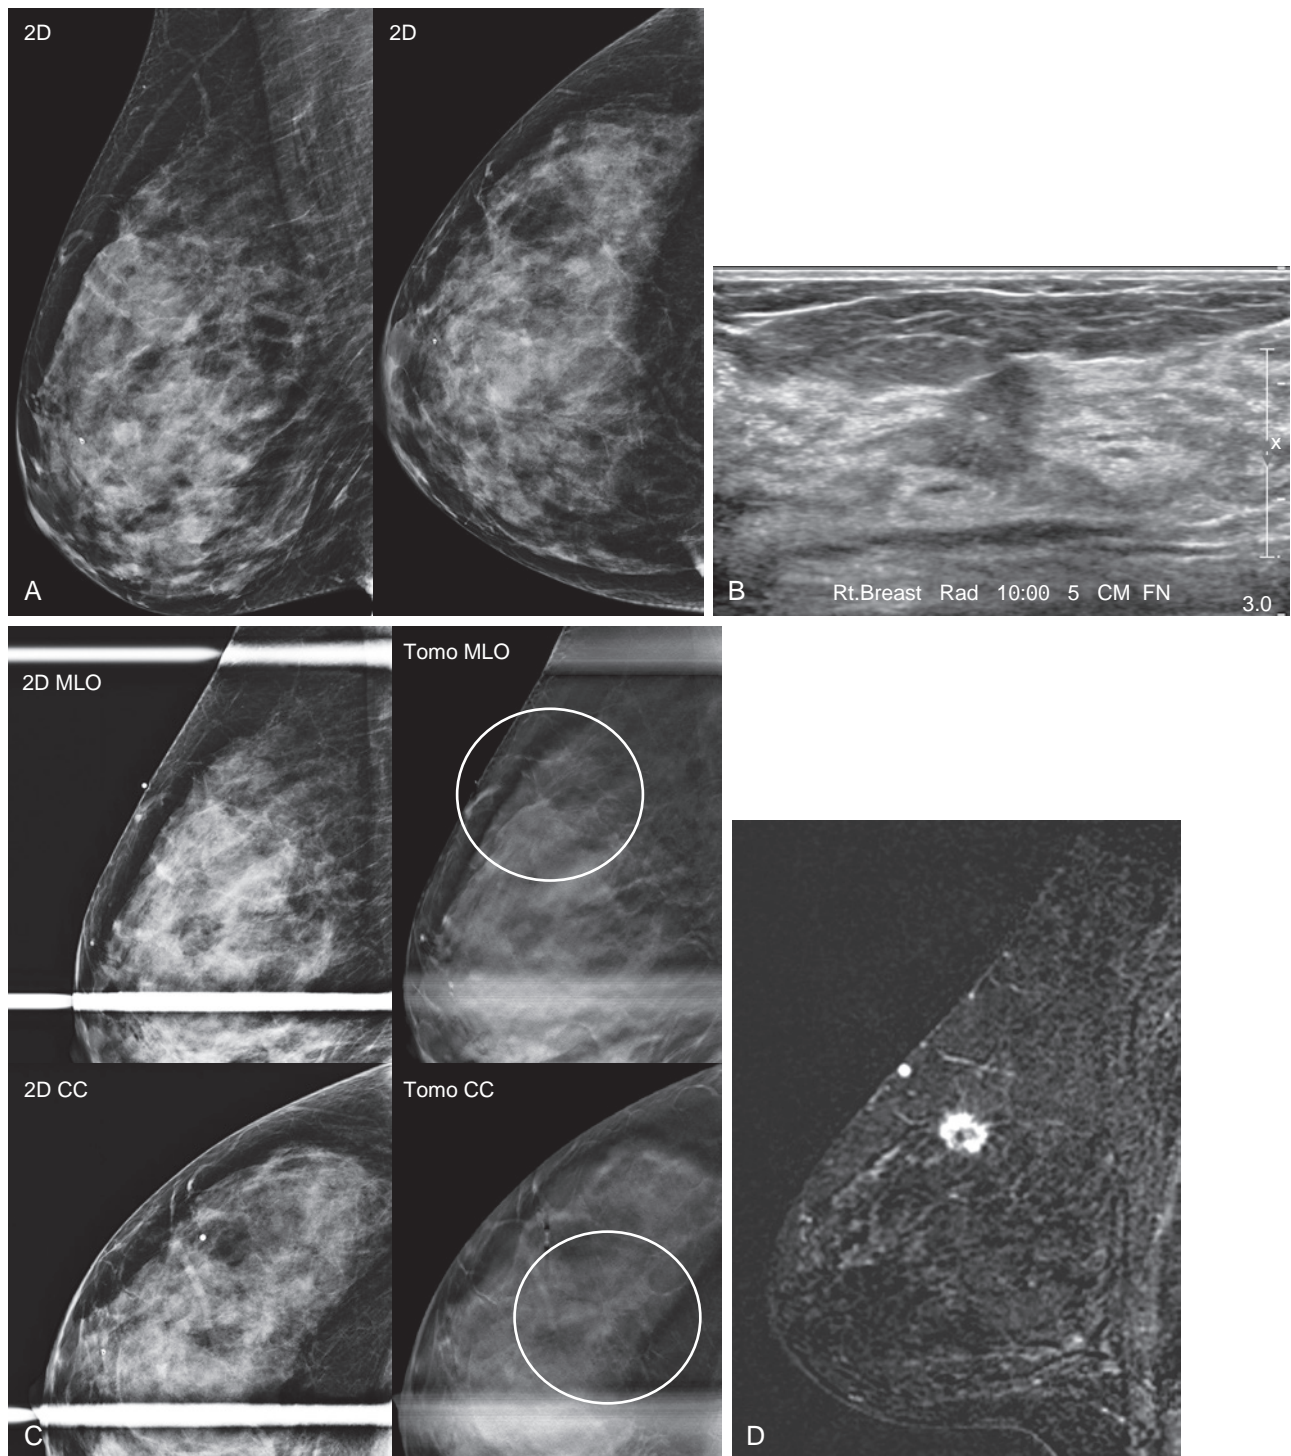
(A) A screening mammogram in a 49-year-old woman with extremely dense tissue was interpreted as normal. (B) Screening ultrasound shows an irregular, hypoechoic mass with spiculated margins in the 10-o'clock region of the right breast. (C) A BB was placed over the lesion, and tomosynthesis spot views demonstrate the spiculated architectural distortion (*circled*) previously undetected. Ultrasound biopsy revealed grade 2 infiltrating ductal carcinoma with ductal carcinoma in situ, ER+/PR+/Her2-. (D) Staging preoperative sagittal, T1-weighted, post-contrast subtraction image from preoperative magnetic resonance shows the spiculated mass to be the only suspicious lesion.
